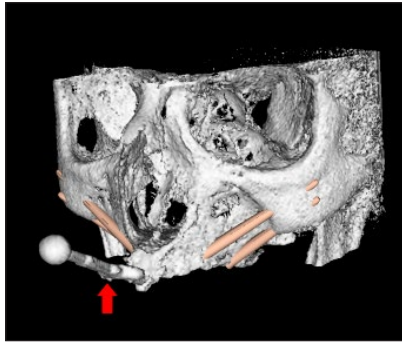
3D virtual planning based on CT scan data with an intraoral navigation system reference plate in situ (red arrow).
